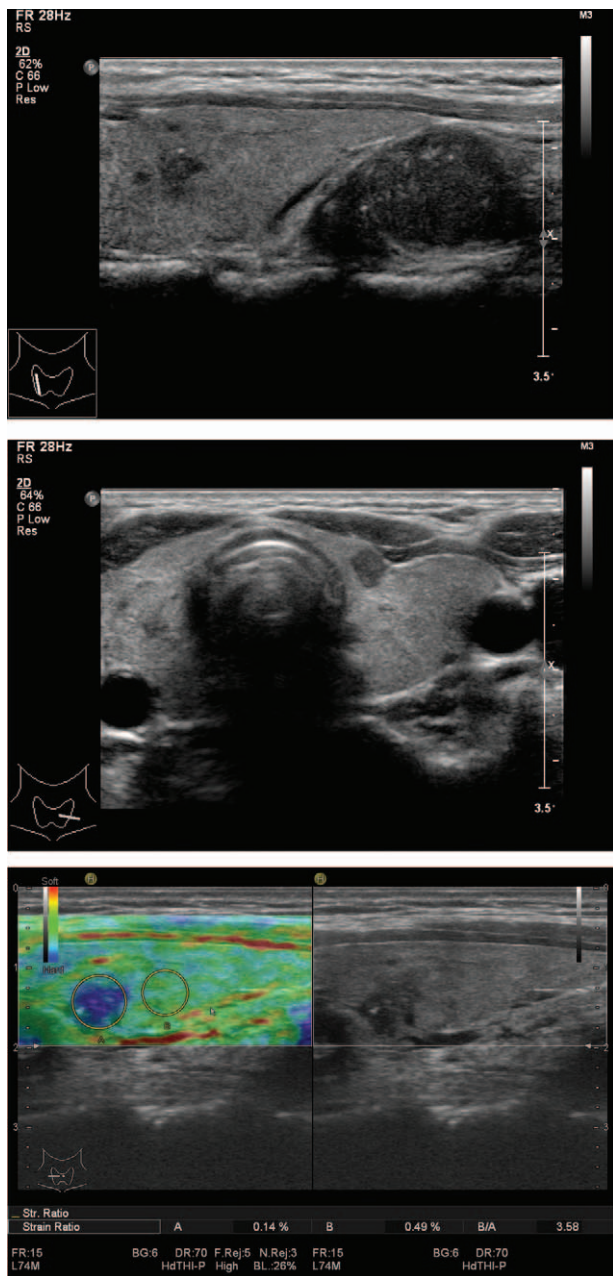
Gray-scale ultrasound image findings: 2 nodules at the bilateral thyroid lobes. A, It was an 8 × 6 × 8 mm size hypoechoic nodule with an irregular shape in the middle lobe of right thyroid. B, This showed other nodules were about 4 × 3 × 4 mm in size, which was hypoechoic, with a mildly irregular shape, a clear margin. C, Figure was an elasticity imaging, which showed the different strain ratios of nodule in the right lobe when compared with normal thyroid parenchyma nearby. The strain ratio of the nodule and the parenchyma was 0.14% and 0.49% respectively, the B/A was 3.58.
